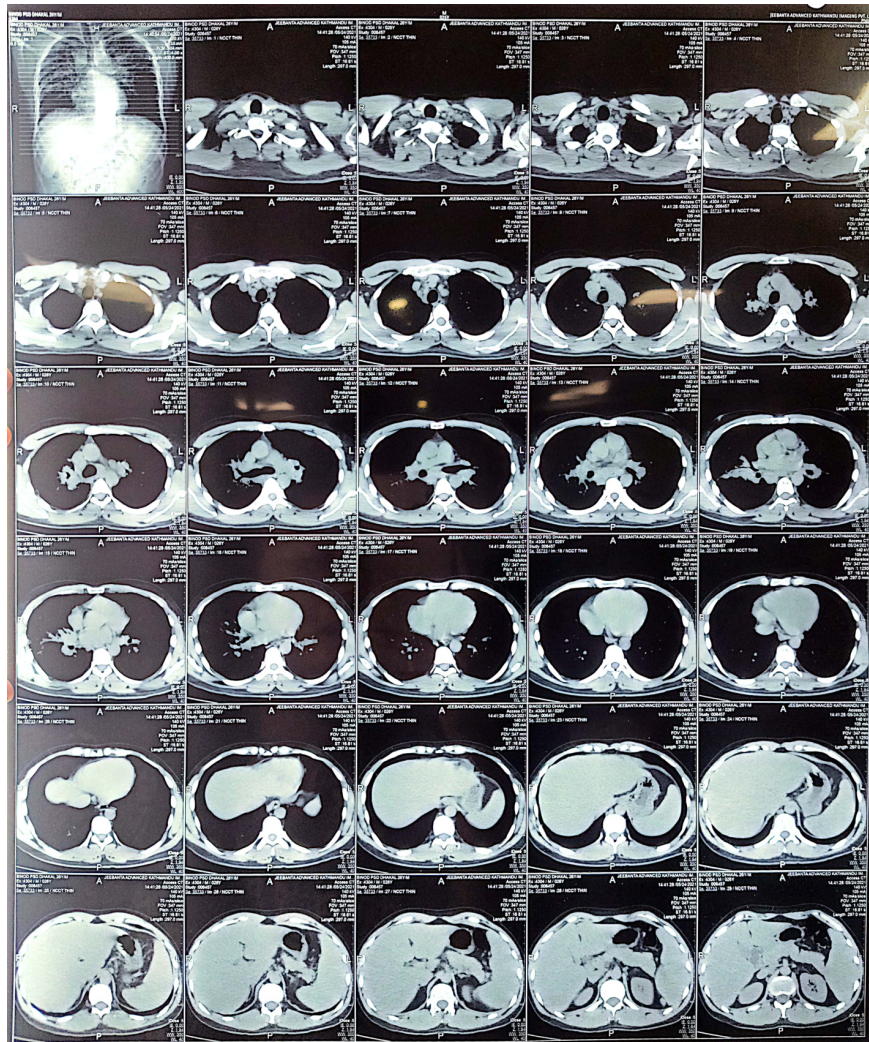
Transverse section of non-contrast Computed Tomography(CT) of the chest revealing discrete and confluent nodular opacities in the bilateral parahilar region involving peribronchovascular and subpleural location and involving all lobes
